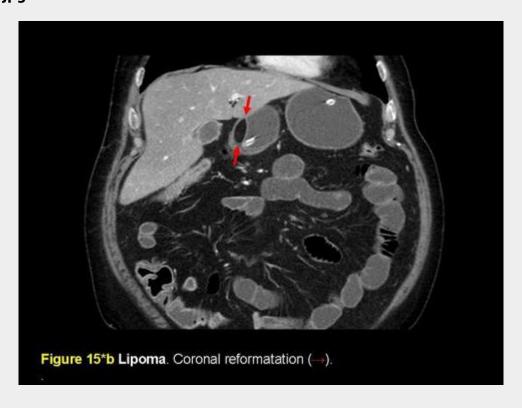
Lipoma (\rightarrow). Post-contrast CT, coronal (*left*) and sagital reformatations (*right*). Note how the normal enhancing submucosal layers of the stomach's wall are interrupted by the fat-attenuation tumor, at it's area of implantation (\rightarrow). Note also the enhancing mucosa overlying it.
